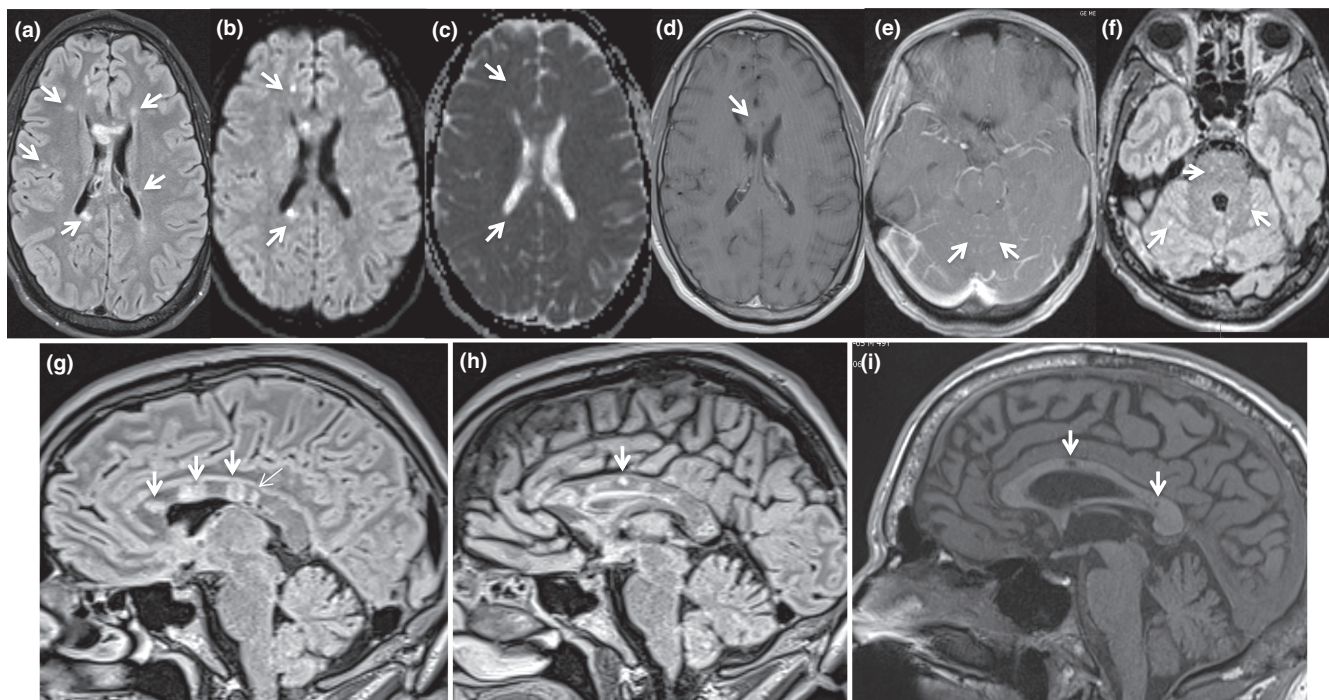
Characteristic MRI findings from patients with Susac syndrome. (a) Axial fluid attenuation inversion recovery (FLAIR) sequence shows typical punctate hyperintensities throughout the white matter (arrows). (b), (c) Axial diffusion-weighted imaging and apparent diffusion coefficient sequence showing punctate areas of restricted diffusion (arrow) corresponding to two of the FLAIR lesions (arrows). (d) Axial T1 post-gadolinium sequence showing partial enhancement of a corpus callosum lesion (arrow). (e) Axial T1 post-gadolinium sequence showing multiple areas of punctate enhancement of the cerebellar meninges (arrows). (f) FLAIR sequence showing further punctate lesions in the brainstem and cerebellum (arrows). (g) Sagittal FLAIR sequence showing three 'snowball' lesions in the corpus callosum (thick arrows) and a thinner 'spoke' lesion traversing the callosum (thin arrow) with (h) an 'icicle' lesion arising from the roof of the callosum (arrow). (i) Sagittal T1 sequence showing typical 'punched out holes' in the corpus callosum (arrows)
